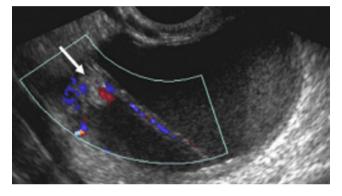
Color Doppler image of an ovarian endometrioma with a nodule and septation demonstrating internal flow (arrow). These nodules may be fibrotic or related to adjacent deformed ovarian parenchyma.⁶
